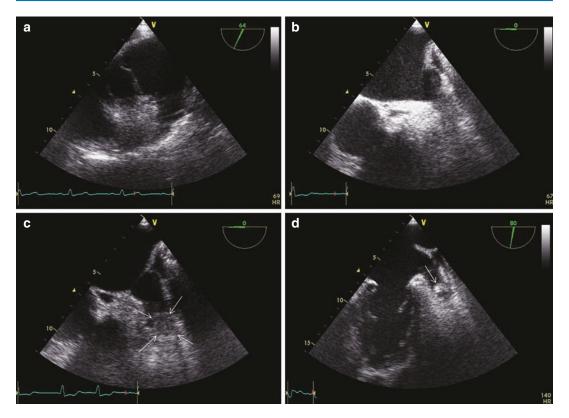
Examples of left atrial appendage shape variability in different individuals, as shown by transesophageal echocardiography in the mid-esophageal view
